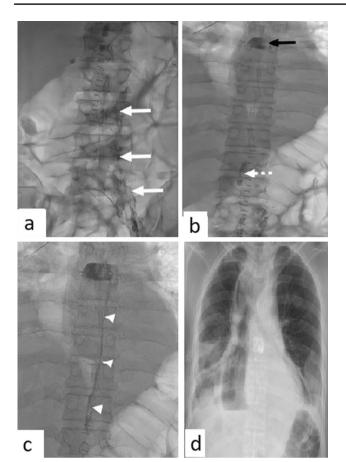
Fluoroscopic images of lymphangiography and embolization: a Opacification of the left-sided lumbar lymphatics (white arrow) following an intranodal injection of lipiodol; b Further follow up showing opacification of the cisterna chyli (dashed arrow) and visualization of the leak in chest (black arrow) corresponding to the surgical site; c Percutaneous fluoroscopy-guided puncture of the cisterna chyli and injection of 50% glue into thoracic duct (arrowhead); d Chest radiograph 24 h post-procedure showing the retention of glue and lipiodol cast
